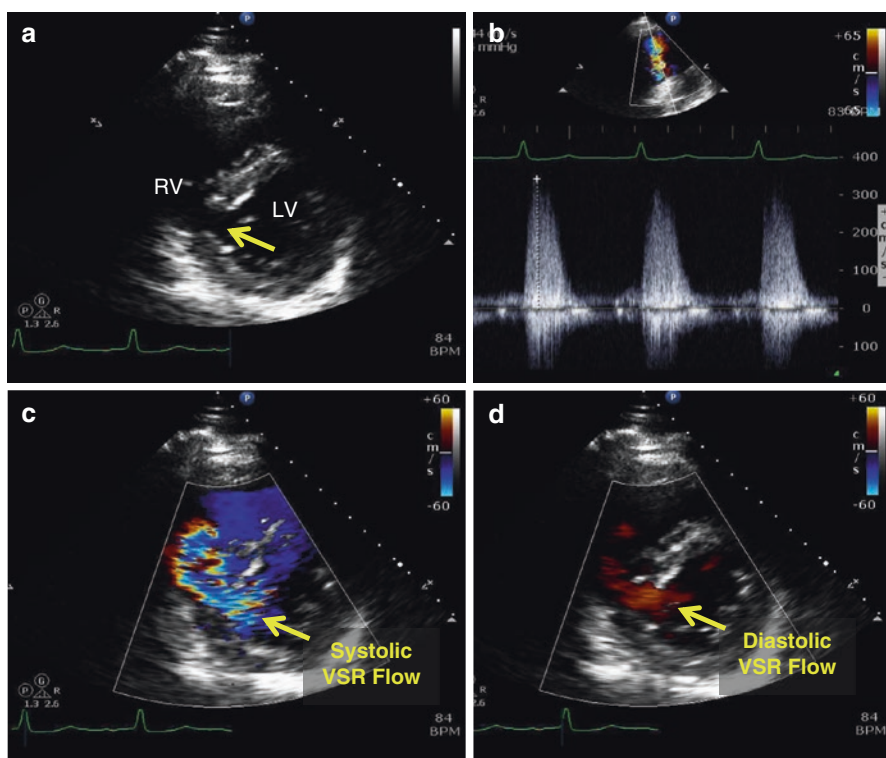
Ventricular septal rupture (VSR) on echo. Panel (a): Parasternal short-axis TTE view of VSR identifying dropout of the ventricular septum. Panel (b): Spectral Doppler confirms high-velocity systolic flow across VSR. Panel (c): Color Doppler imaging showing high-velocity systolic flow across VSR. Panel (d): Color Doppler imaging showing low-velocity diastolic flow across VSR. In this condition, a harsh holosystolic murmur is typically heard. *Abbreviations:* LV left ventricle, RV right ventricle, VSR ventricular septal rupture
